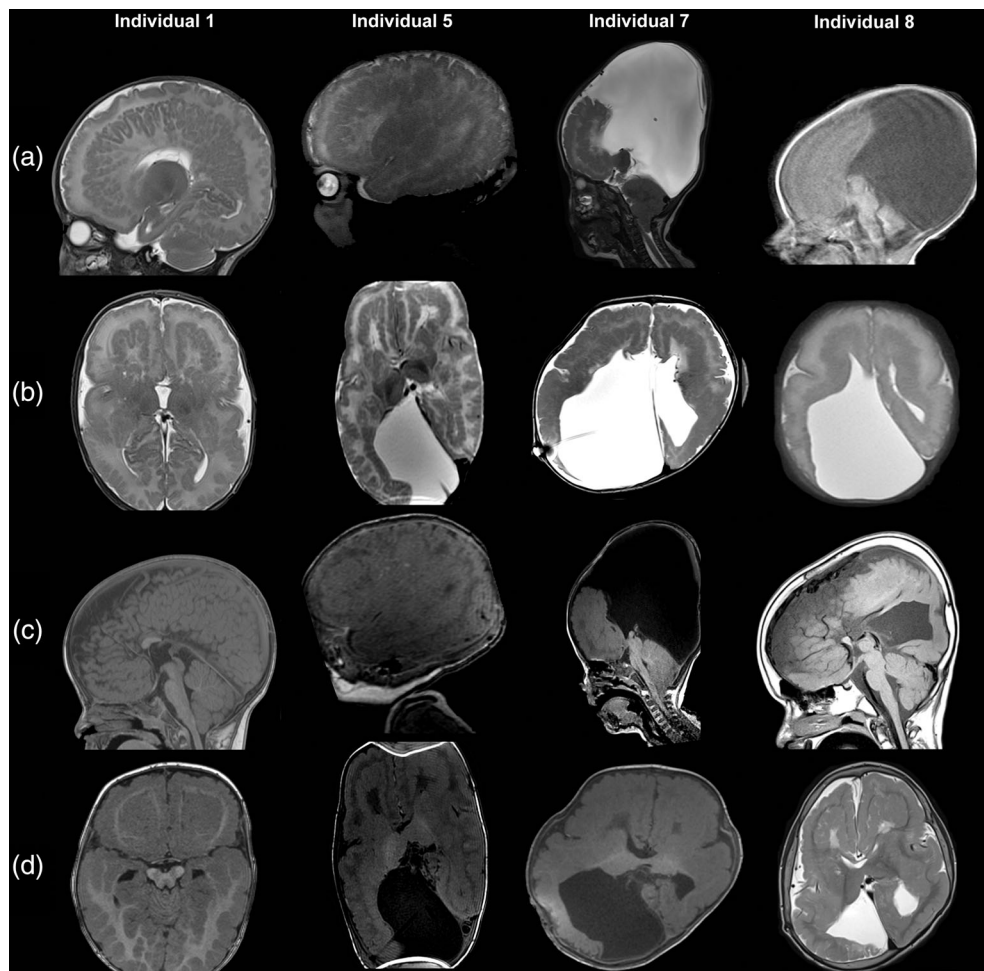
Brain MR imaging of Individuals 1, 5, 7, and 8. Individual 1 a-b: Sagittal and axial T2 scans at 39 days of life demonstrates thin cortex with shallow polygyria; symmetrical undulating ribbon-like heterotopia is also noted in the subcortical region. (c, d) Axial and sagittal T1 weighted scans at age 13 months demonstrate myelinated white matter on both sides of the ribbon-like heterotopia in the periventricular regions and the subcortical regions. The sagittal T1 midline image (a) at 13 months shows further head growth with bossing of forehead. The corpus callosum is hypoplastic. There is progression of myelination and development of macrocerebellum with large vermis and ectopic cerebellar tonsils. The pons is flat and the midbrain is short. Individual 5 a-d: Sagittal and axial T2 (a, b) and T1 (c, d) weighted images obtained at 4 months of age show the same typical ribbon-like heterotopia with overlying polymicrogyric cortex. There is frontal bossing and an enlarged right occipital horn. Note the medial fusion of small and rotated thalami (b, d). On the sagittal T1 (c) high signal areas are visible, which are low on T2. Individual 7 A-D: Sagittal and axial T2 (a, b) and T1 (c, d) weighted images at age 11 months show macrocephaly with extreme enlargement of the occipital horns, right more than left with compression on the tentorium and posterior fossa with tonsillar herniation through foramen magnum. The ribbon-like heterotopia and abnormal dysgyric overlying cortex are seen in all lobes. Note also the medial fusion of the dysmorphic thalami (d). Partial callosal agenesis with presence of a very thin rostrum and genu was noted. Individual 8 a-d: Sagittal T1 (a, c) and axial T2 (b, d) weighted images at age 5 days (a, b) and 8 years (c, d). Note the large interhemispheric cyst communicating with the occipital horn of the right lateral ventricle (a, b), partial agenesis of the corpus callosum (a, c). Postnatally, the thin dysplastic cortex with shallow sulci and the ribbon-like heterotopia is easily noted (b). The basal ganglia are severely hypoplastic and the thalami are fused (d). Note also the patchy white matter changes especially in the frontal lobes (d)
